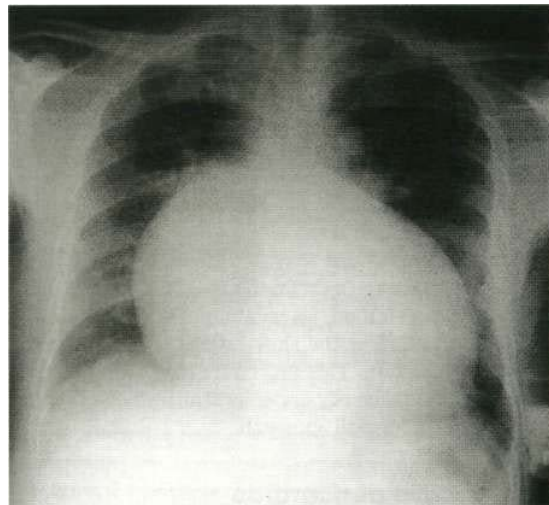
Chest X-ray showing a pericardial effusion; the heart appears globular.
